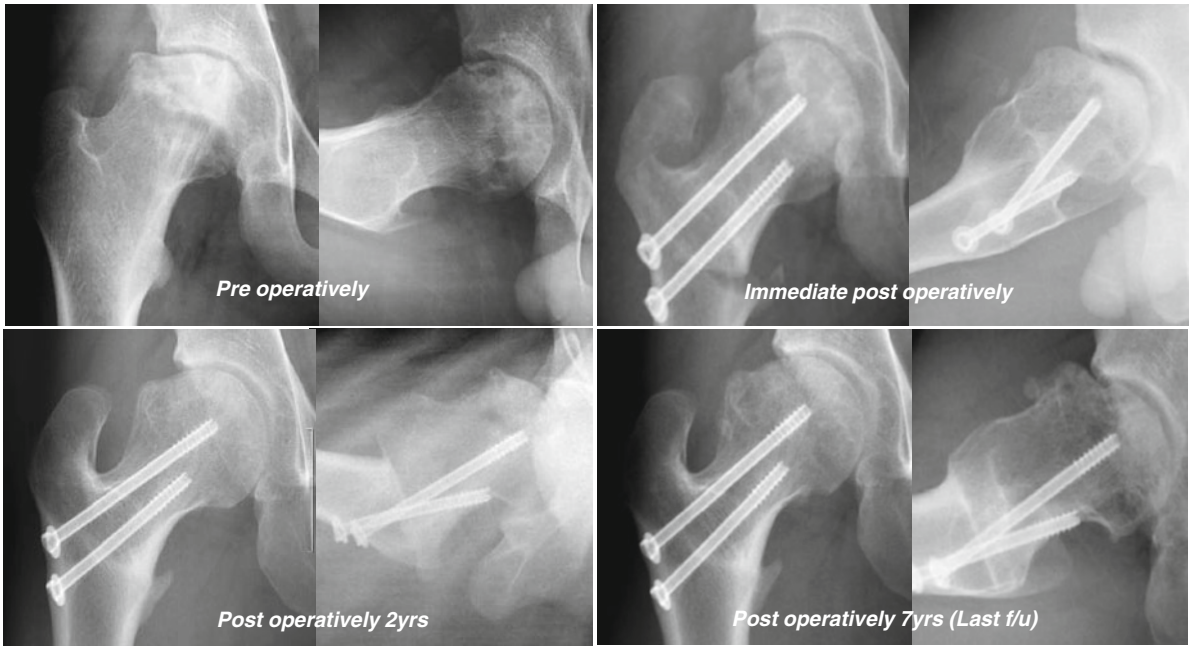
Serial radiographs of anterior rotational trochanteric osteotomy from a 16-year-old man with posttraumatic osteonecrosis of the femoral head are shown
